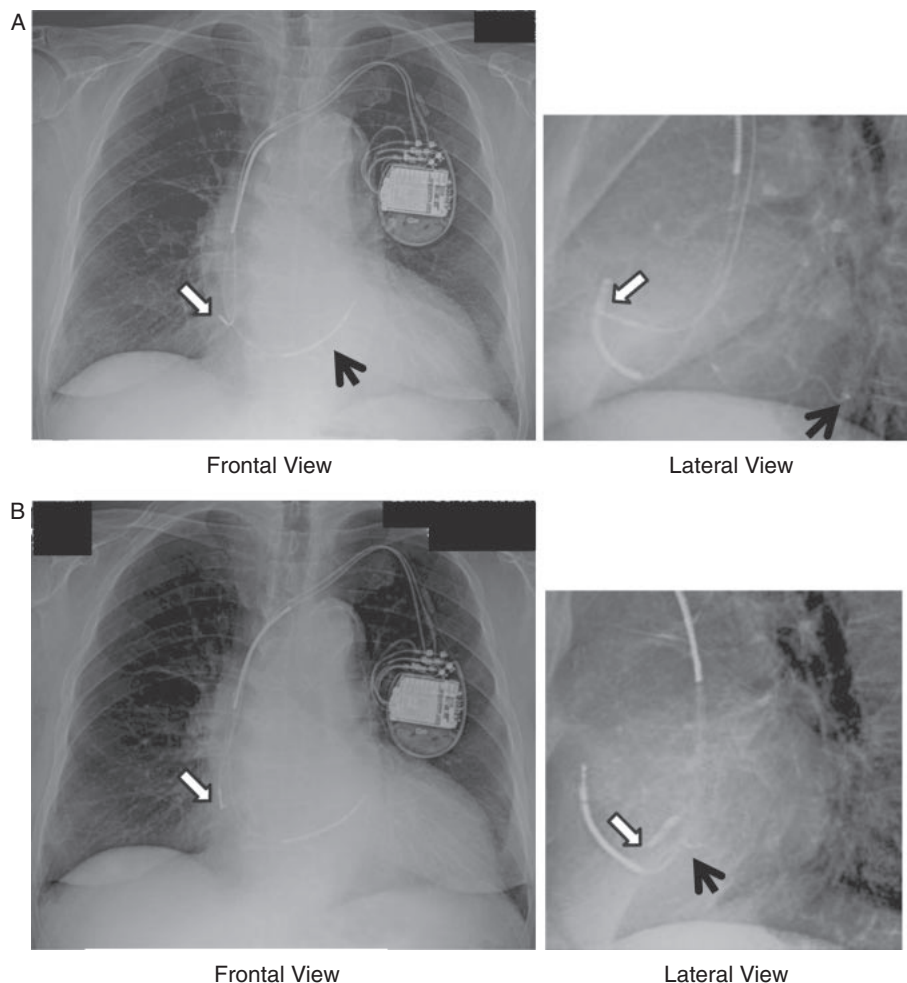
Chest X-rays taken immediately after implantation of a CRT-D (A) and one month later (B).
